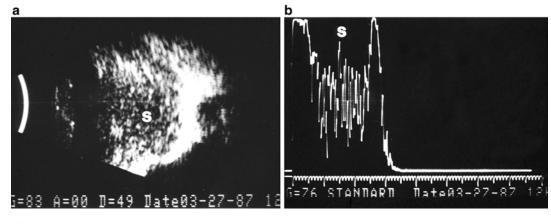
(a) B-scan ultrasound of a patient with acute dacryocystitis demonstrating a massively enlarged nasolacrimal sac (S) and thickened anterior and posterior walls. (b) A-scan ultrasound of the same patient as
